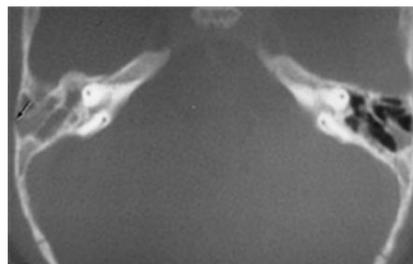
Coalescent otomastoiditis, subperiosteal abscess. Axial CT scan temporal showing debris that penetrated the mastoid with the mastoid septa affected when compared to the contralateral
